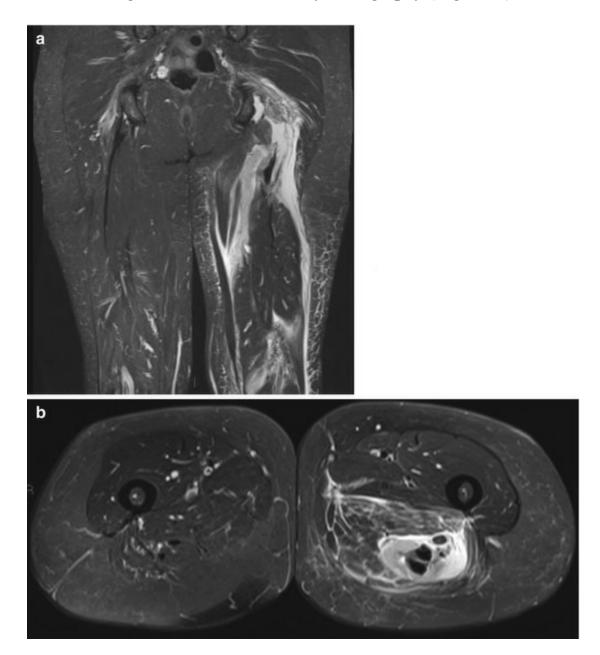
A 66-year-old woman with complete proximal hamstring avulsions after trauma. (a) Coronal STIR MRI shows torn and retracted hamstring tendons. Note the presence of a fluid-filled gap at the ischial tuberosity, indicating the avulsion site. (b) Axial STIR MRI reveals a large intermuscular hematoma
